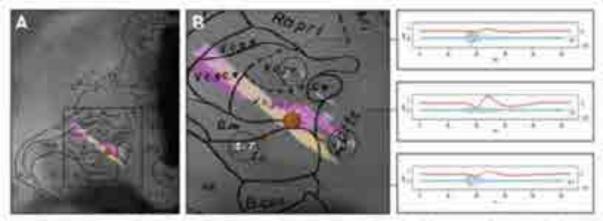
Directional SSEP amplitude correlated with anatomical images. On the left: fusion of preoperative MRI with postoperative GT projected onto stereotactic human brain atlas. On the right: low frequency component (red), and high frequency component (blue) for the three bipolar montages of one patient.
